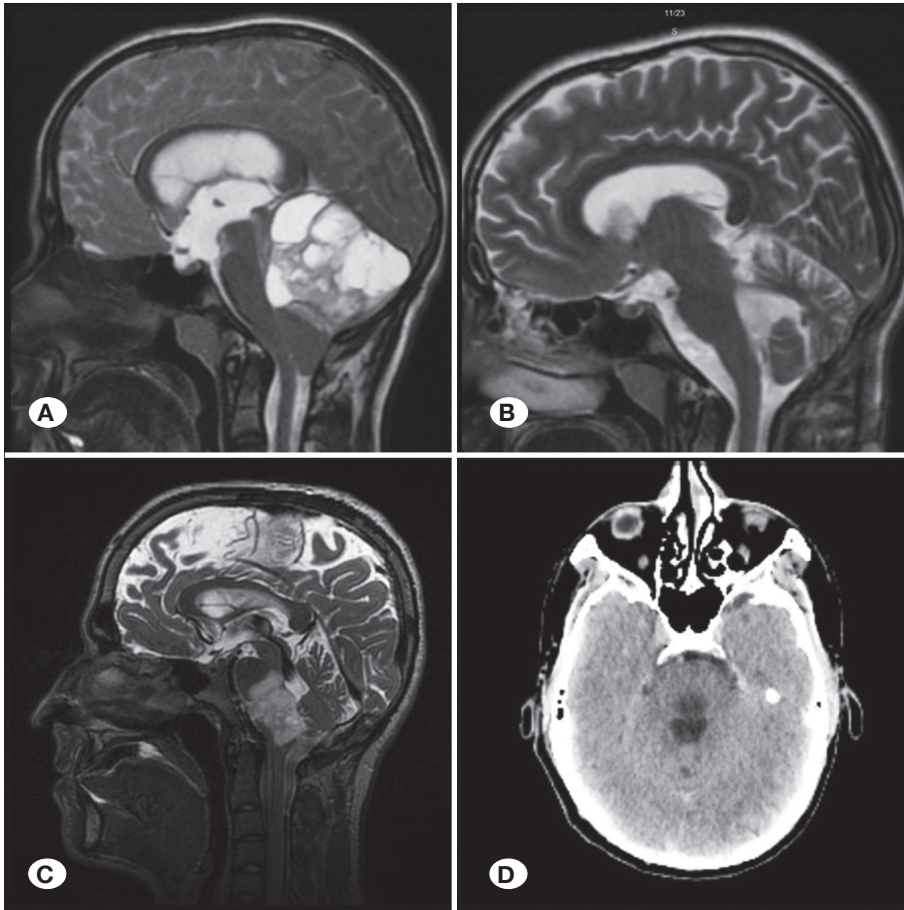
Patient #15. Dorsal exophytic medullary tumor. A and C) Preoperative T2W sagittal MRIs. Postoperative B) sagittal T2W MRI and D) axial CT images. No recurrence observed on postoperative imaging.
